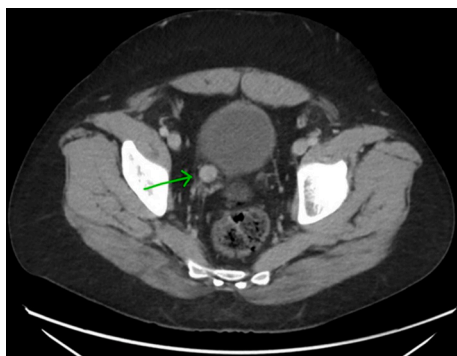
Axial CT - Ovoid enhancing lesion in the distal right ureter.
